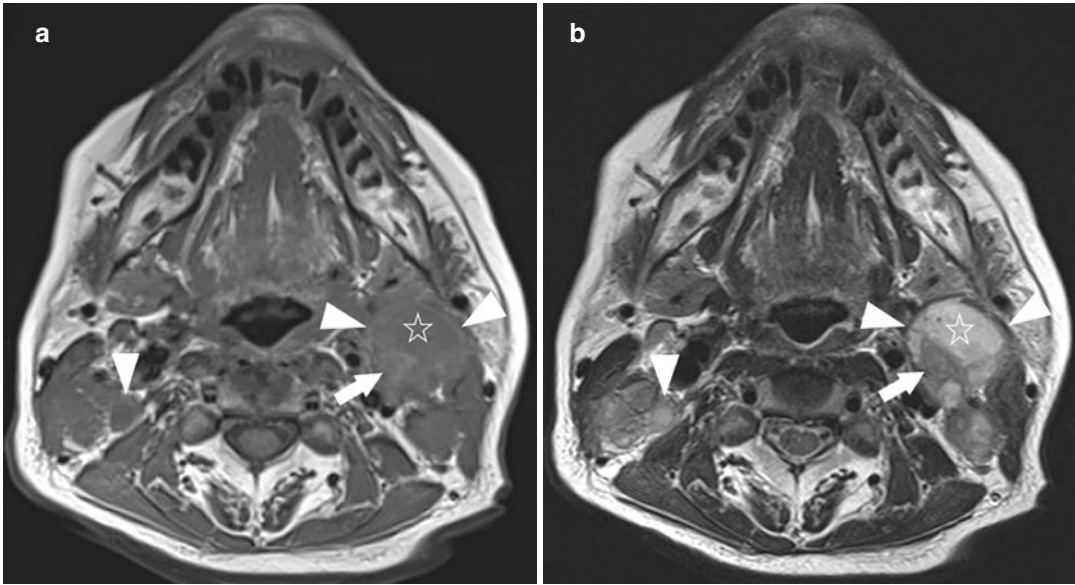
MRI of tuberculous lymphadenitis. Axial (a) T1-W and (b) T2-W MR images show bilateral cervical lymphadenopathy. The necrotic area appears
